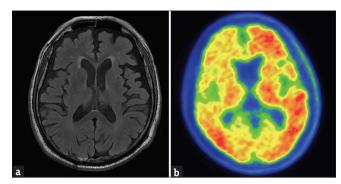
(a) Brain magnetic resonance imaging of P13 at age 67 that shows prominent cerebral sulci, ventricles, and cisterns, indicating brain atrophy. (b) Florbetaben positron emission tomography of P19 at age 70. It shows uptake of Florbetaben, an 18F-labeled polyethylene glycol stilbene derivative with high affinity and specificity for β-amyloid plaques, indicating abnormal brain deposition of β-amyloid plaques
